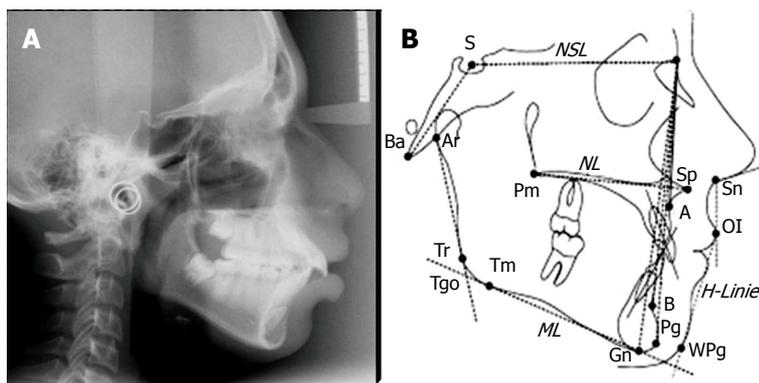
Cephalometric radiographs show the entire side of the head and help to evaluate the spatial relationships between cranial and dental structures. A: A lateral cephalometric X-ray is useful to determine cranio-facial structures and their relationship with position of the jaws and teeth; B: Different landmarks used to evaluate the planes and angles formed, to arrive at a diagnosis and treatment planning for orthodontic treatment/orthognathic surgery. Serial cephalograms can give the amount and direction of growth of facio-maxillary complex.
